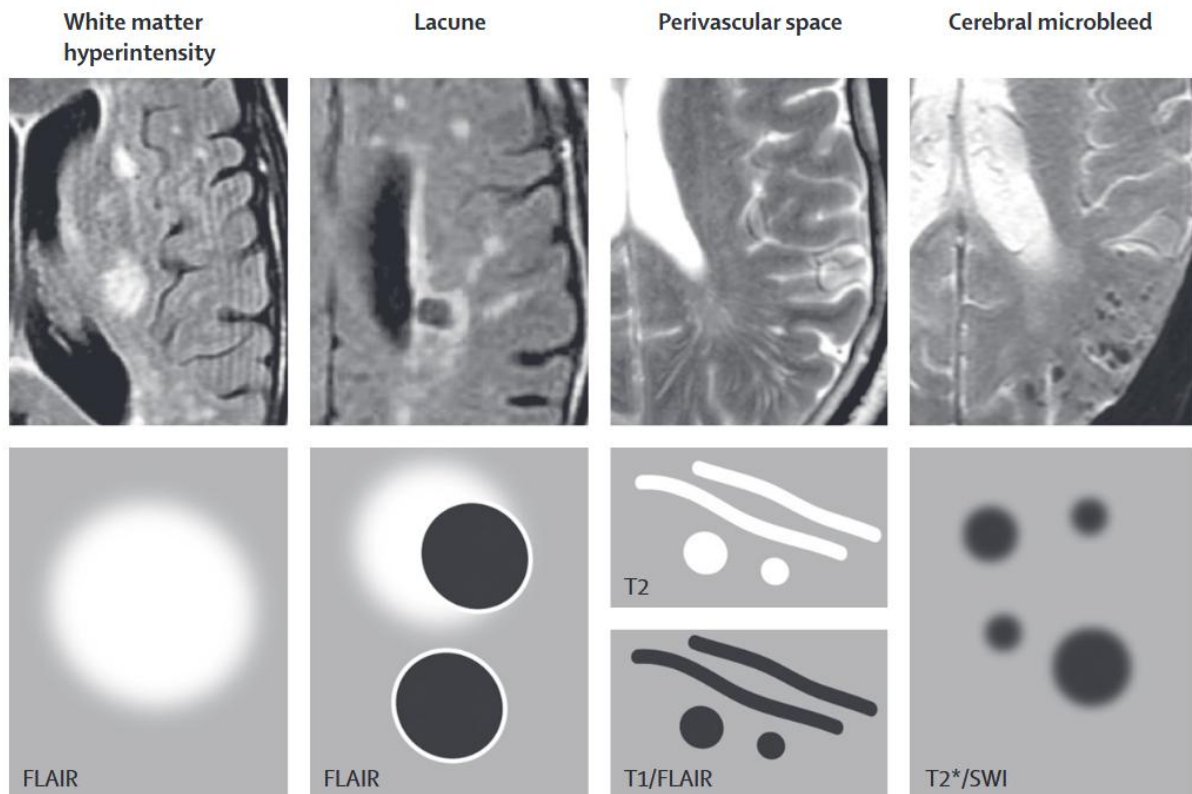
The four key MRI indicators of cerebral small vessel disease.² Abbreviations: FLAIR (fluid-attenuated inversion recovery); SWI (susceptibility-weighted imaging).
